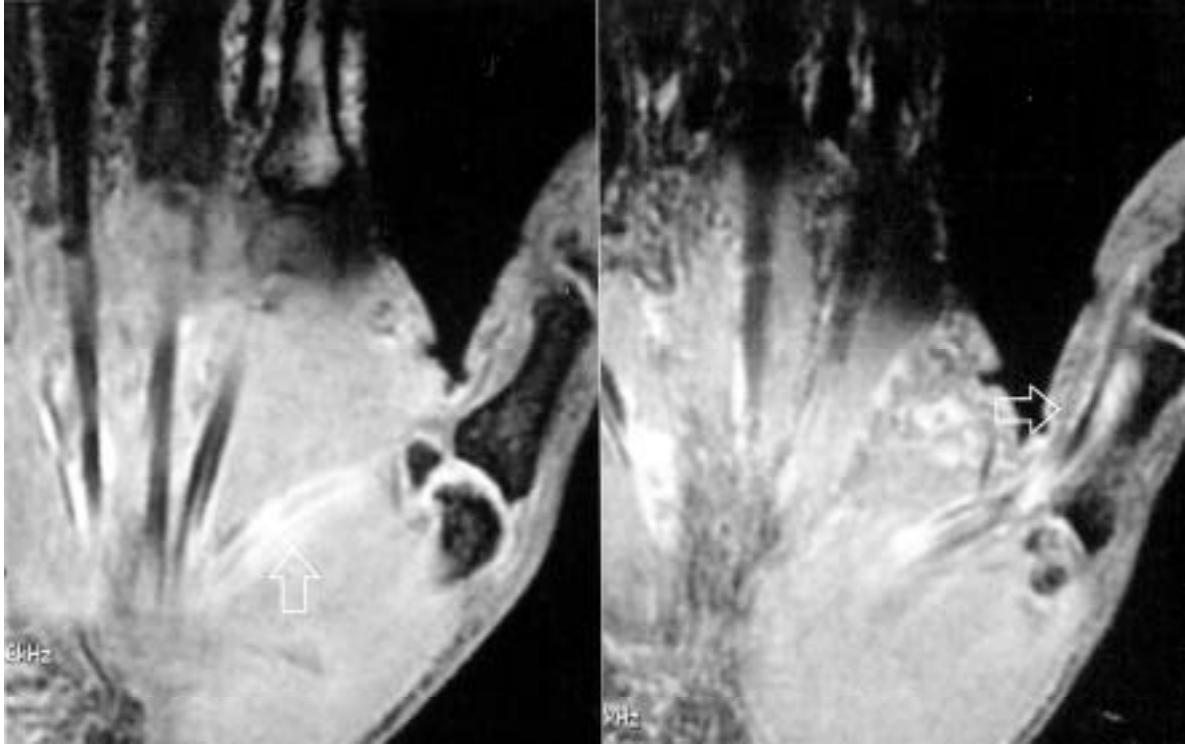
Coronal T2-weighted image showing fluid in the flexor synovial sheaths of the first right finger (arrow) extending without any interruption into the thenar eminence (arrow).
